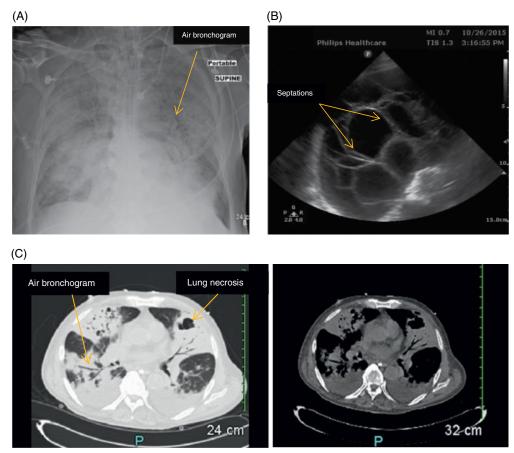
(A) Chest radiograph of an ICU patient with severe influenza pneumonia and superimposed MRSA pneumonia. Note the multilobar opacities with air bronchograms indicating consolidation. (B) Ultrasound of same patient whose small pleural effusion developed into a larger, loculated, and septated parapneumonic effusion. (C) CT chest of same patient demonstrating multilobar consolidation, necrotizing pneumonia, and small pleural effusions.
